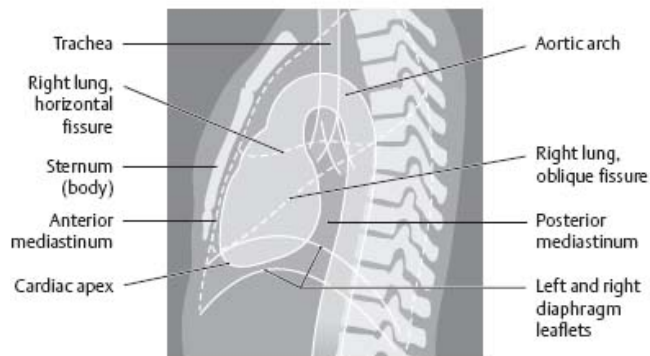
Radiographic appearance of the heart
